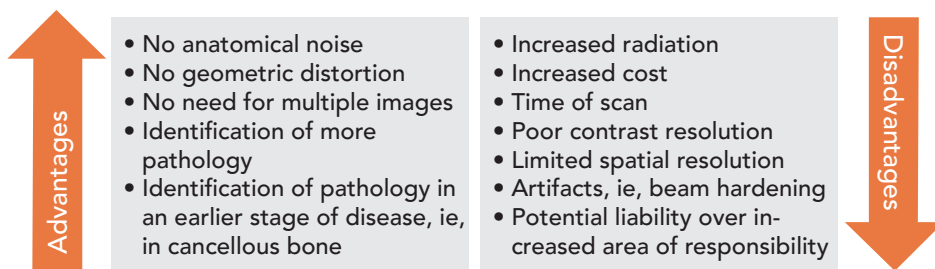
The advantages and disadvantages of CBCT imaging compared with 2D dental imaging techniques.
